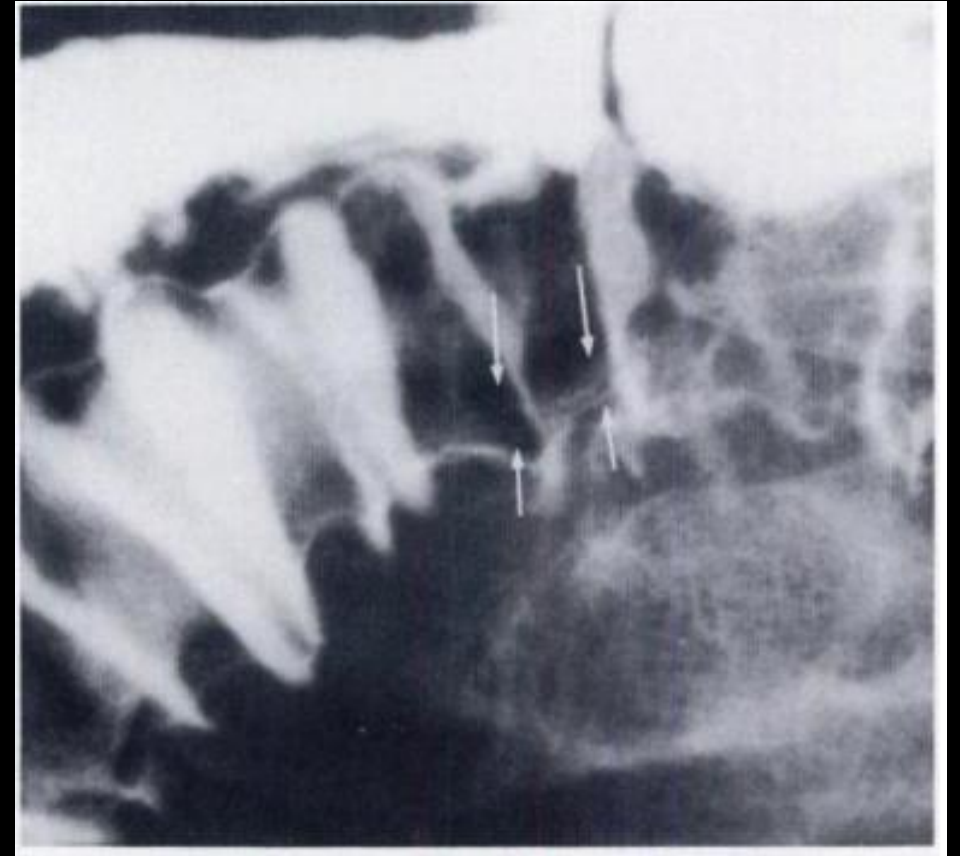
Double-contrast radiograph of ileum. From Matsui T, Iida M, Murakami M, et al. *Intestinal anisakiasis: clinical and radiologic features. Radiology.* 1985;157(2):299-302.
